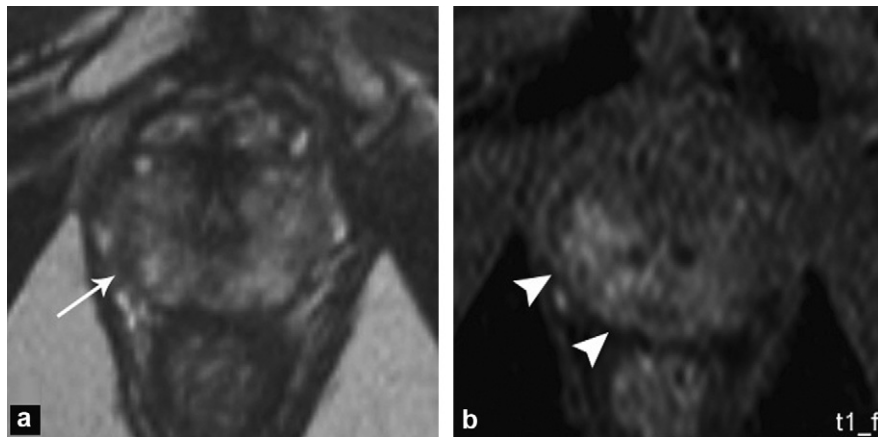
A 73-year-old patient treated with external beam radiotherapy for prostate adenocarcinoma 8 years previously. The nadir PSA was 0.85 ng/mL 2 years after radiotherapy, then the level gradually climbed again to 1.67 ng/mL. Biopsies of the prostate showed a Gleason 6 adenocarcinoma in the right apex, right and left mid parts of the prostate: a: T2-weighted axial magnetic resonance imaging (MRI) shows a suspect hypointense area in the right mid part of the peripheral zone (arrow); b: dynamic axial slice after contrast agent injection shows early enhancement of the apex and the right mid part crossing the midline towards the left (arrowheads).
